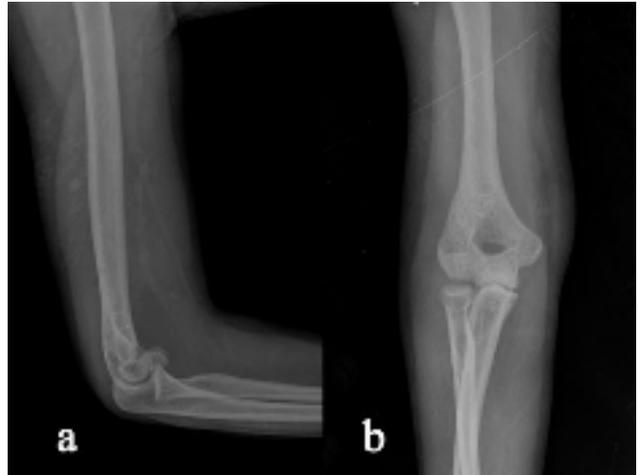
Anterior-posterior and lateral radiographic views of the elbow
